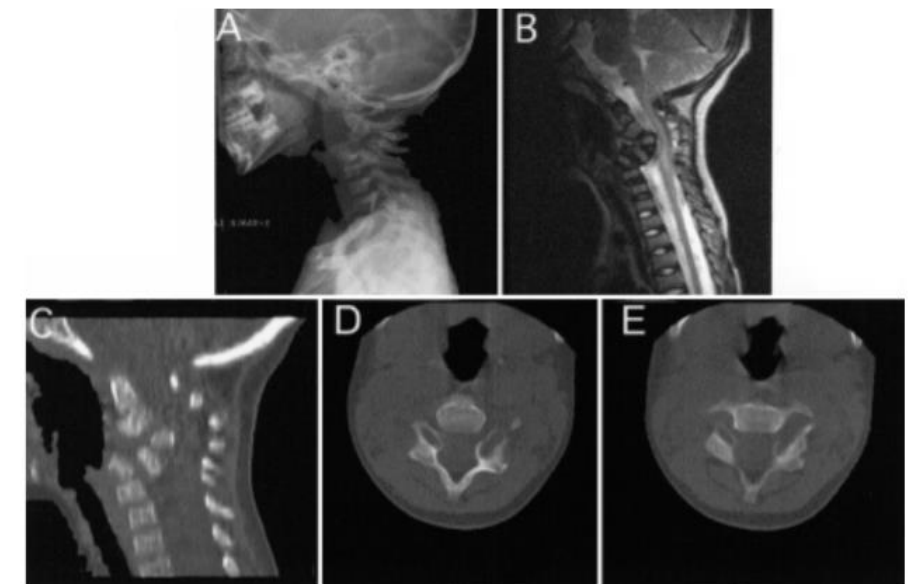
Case 2. Plain lateral x-ray film (A) and sagittal CT scan (C) depicting the buckling deformity of the neck, with the spinal cord compression ventrally as shown in the sagittal MR image (B). The absence of an osseous bridge between the anterior and posterior elements and the enlarged and abnormally shaped foramen transversarium are seen in axial CT scans (D and E).
